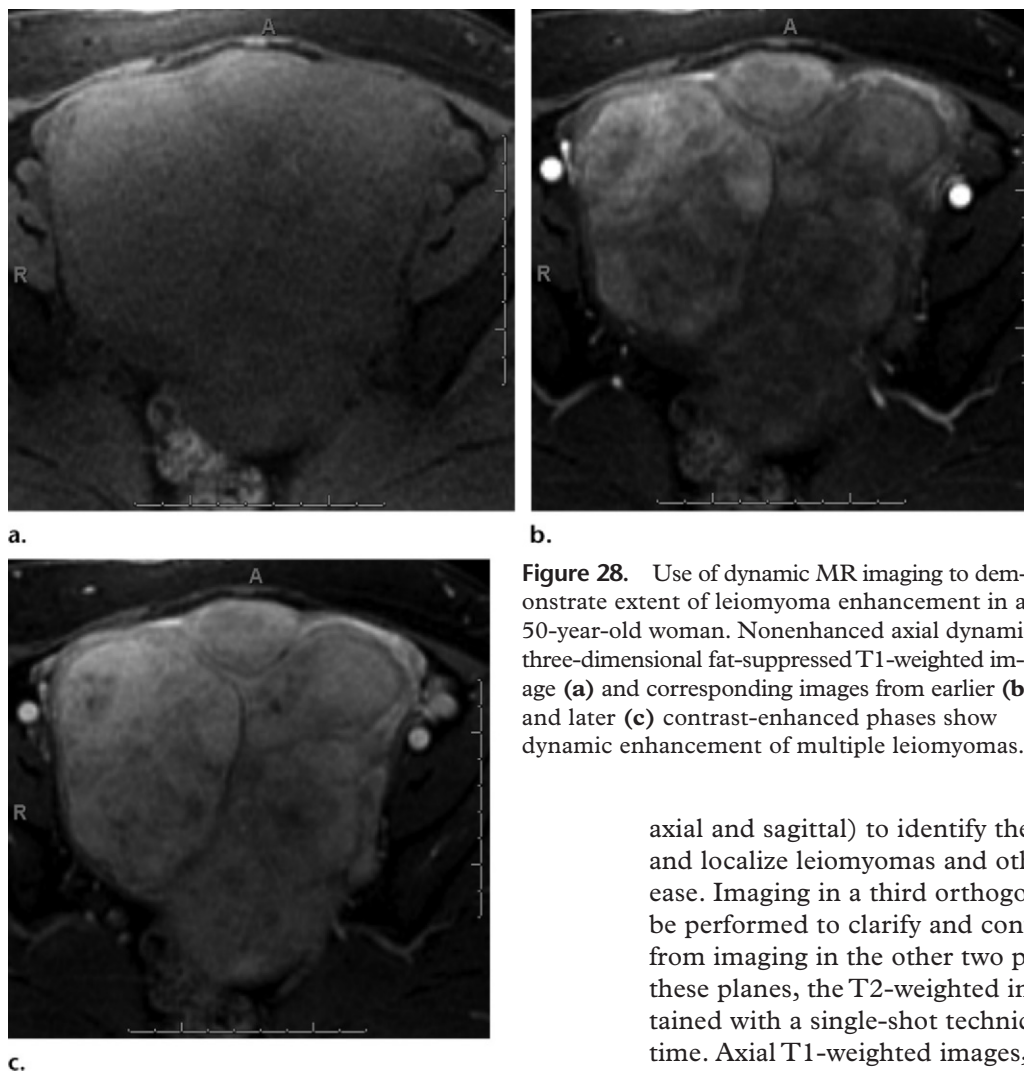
Use of dynamic MR imaging to demonstrate extent of leiomyoma enhancement in a 50-year-old woman. Nonenhanced axial dynamic three-dimensional fat-suppressed T1-weighted image (a) and corresponding images from earlier (b) and later (c) contrast-enhanced phases show dynamic enhancement of multiple leiomyomas.
